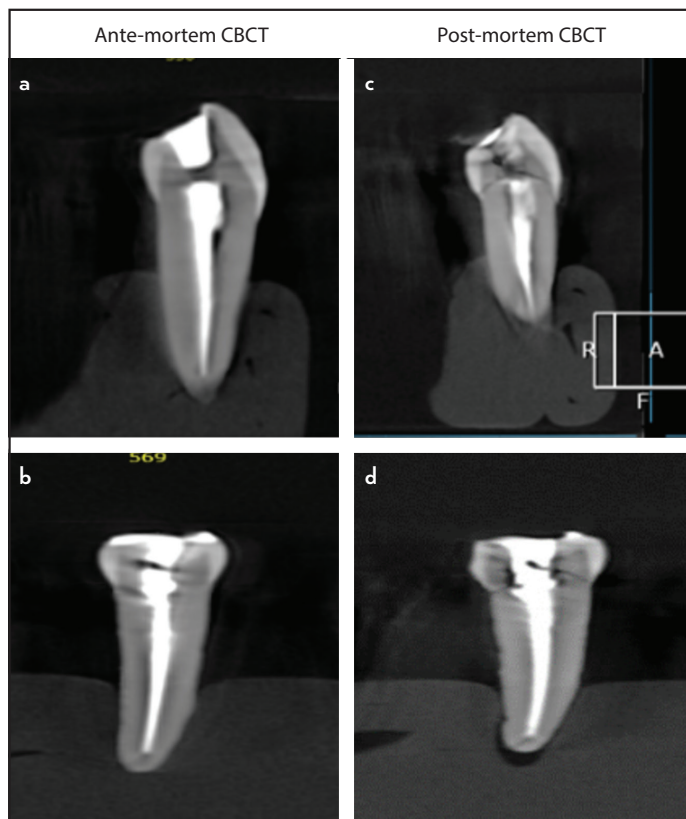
CBCT evaluation of the ante-mortem CBCT records (a, b) and the post-mortem CBCT records (c, d) of the endodontically treated teeth for forensic analysis at 400°C
